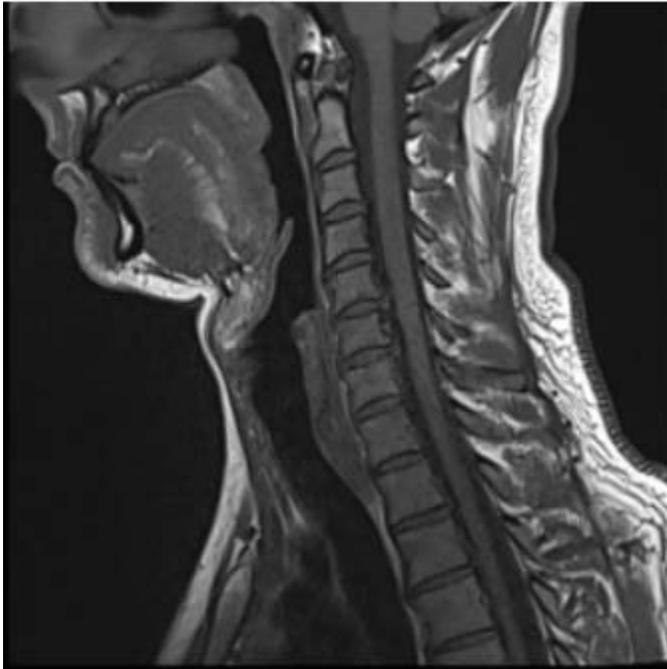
T1 weighted sagittal MRI
